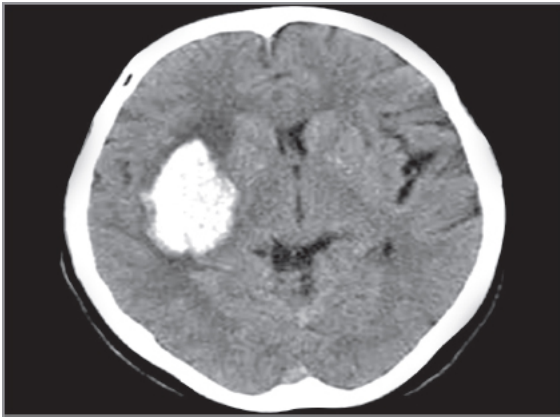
Plain CT head showing hyperdense shadow in the right basal ganglia suggestive of acute intraparenchymal hemorrhage.
